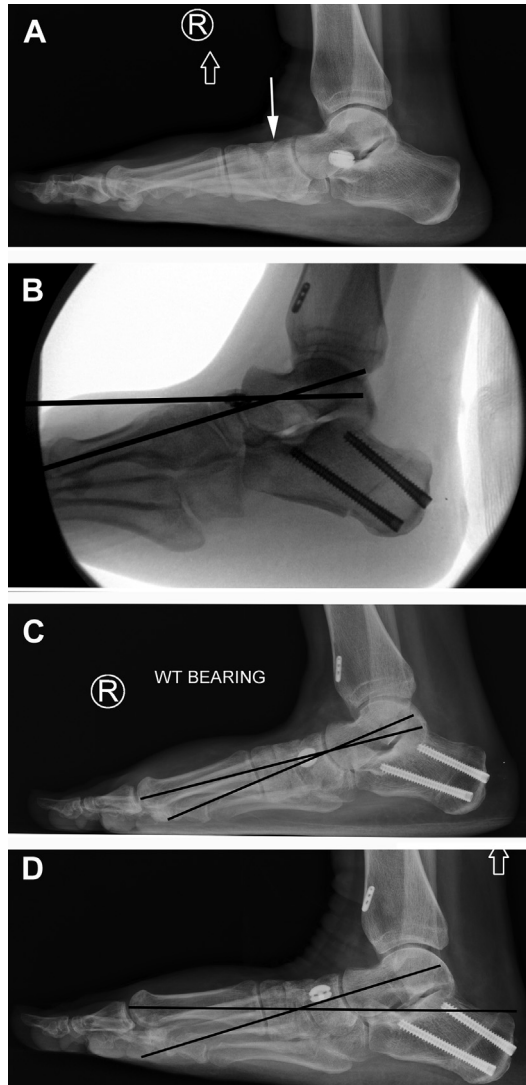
Preoperative lateral radiograph (A) of a patient who failed a prior sinus tarsi implant procedure and who presented with persistent symptomatic complaints with evidence of NC collapse (*white arrow*). Intraoperative correction (B) was performed with a medial slide calcaneal osteotomy (medial displacement calcaneal osteotomy [MDCO]), FDL tendon transfer, gastrocnemius recession, and allograft spring ligament reconstruction. Correction was thought to be appropriate with elevation of the talar head. Three-month postoperative (C) radiographs note mild loss of correction through the NC joint. However, at 6 months (D), note the increasing loss of correction through failure of the NC joint. In hindsight, an isolated NC fusion may have been more appropriate in this patient as opposed to a spring ligament reconstruction.
